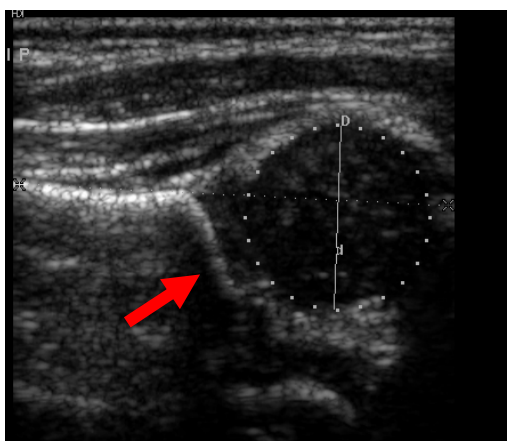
normal left hip ultrasound scan of a 3 month old girl. The femoral head is located within a well formed acetabulum.
